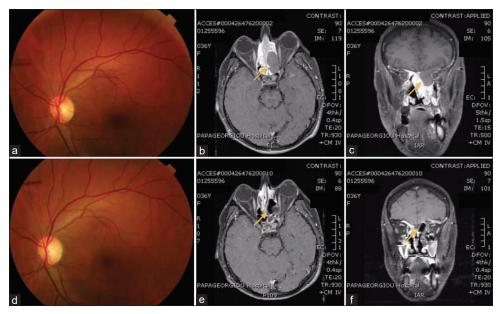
(a) Fundus photograph at baseline. No signs of optic nerve compression are noticed (b and c) magnetic resonance imaging (fat-saturated post contrast T1-weighted axial and coronal cuts, respectively) at presentation depicting an iso-dense bilobed cystic lesion lateral to the ethmoid sinuses, compressing the optic nerve inferomedially (orange arrow) (d) Fundus photograph at week 4 postoperatively. Progression of optic nerve pallor is noted (e and f) magnetic resonance imaging (fat-saturated post contrast T1-weighted axial and coronal cuts, respectively) at week 1 postoperatively. The area corresponding to the evacuated cyst is marked with the orange arrow
